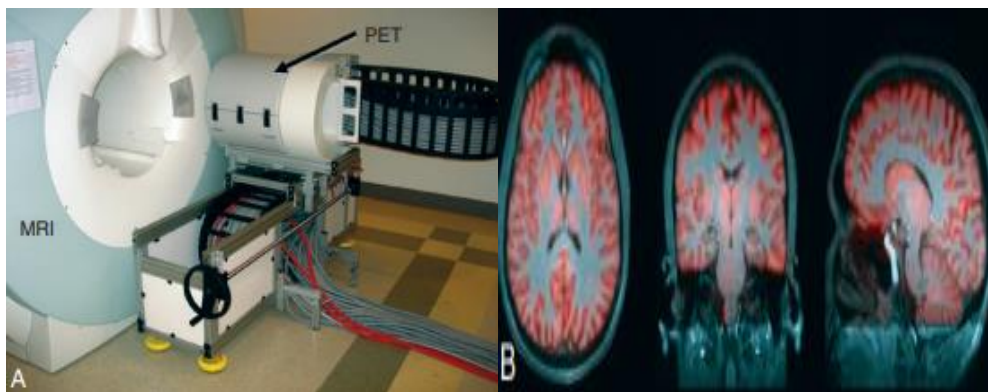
(A) Hybrid PET/MRI scanner. The PET scanner is inserted inside the bore of the magnet to allow simultaneous acquisition of PET and MRI images of the brain. The field strength of the MRI scanner is 3 T, (B) simultaneously acquired ^{18}F -fluorodeoxyglucose.
